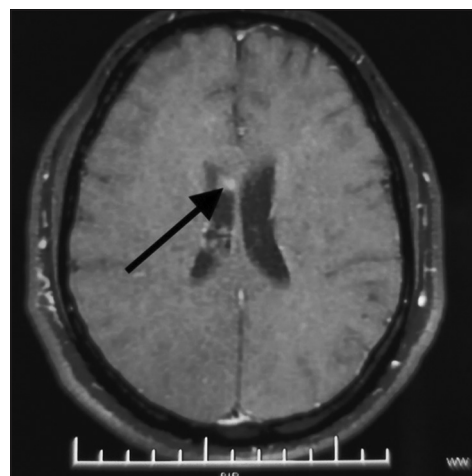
Post-contrast axial magnetic resonance imaging showing right endypmal nodular enhancement (arrow)
